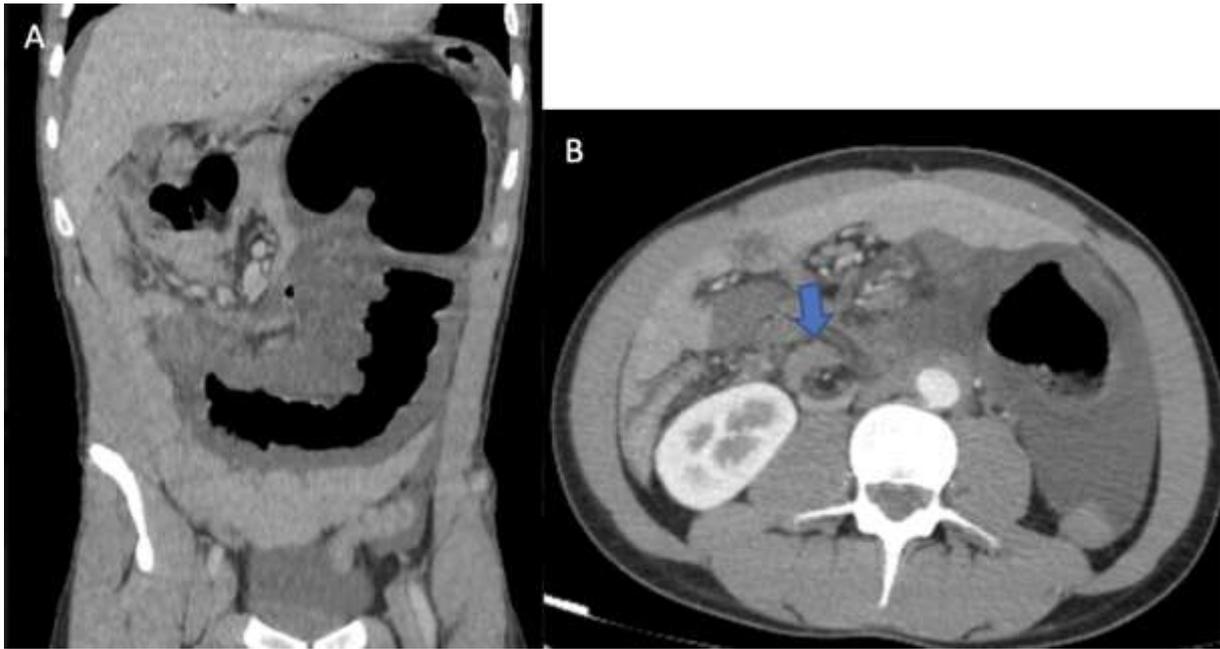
Portal phase CT scan of the first patient in the coronal plane (figure A) and axial plane (figure B), showing significant cecal distention and the 'whirlpool sign' (arrow in figure B)
